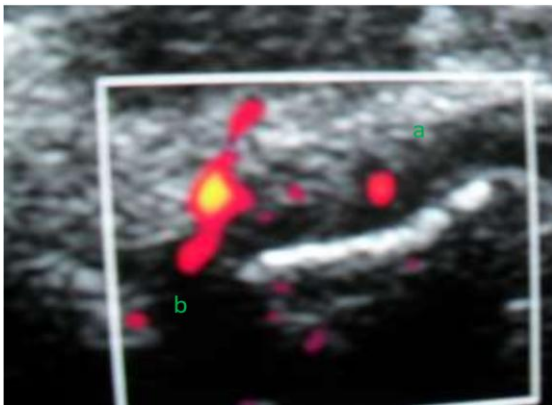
showing a transverse scan of the dorsal aspect of left wrist joint of RA patient with synovial hypertrophy (a), and moderate vascularity is seen as power Doppler signal of grade 2 (b).
